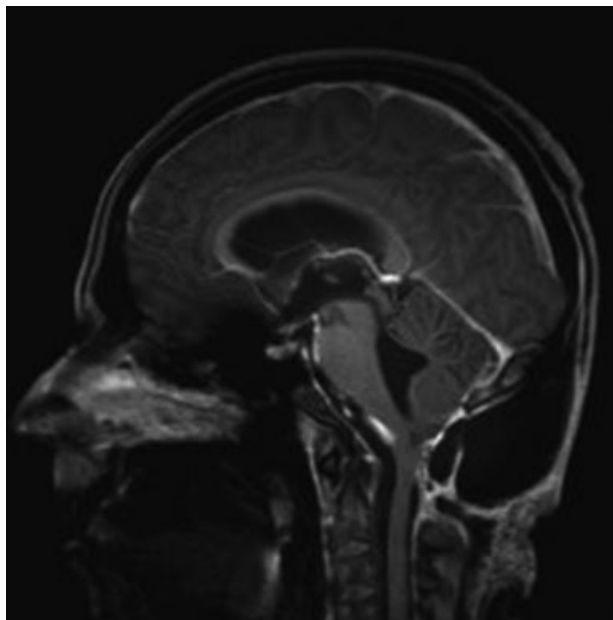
Postoperative encephalon T1-weighted MRI scan with contrast, in the sagittal section, showing complete resection of the tumor lesion, with centralization of the brainstem and free fourth ventricle.
